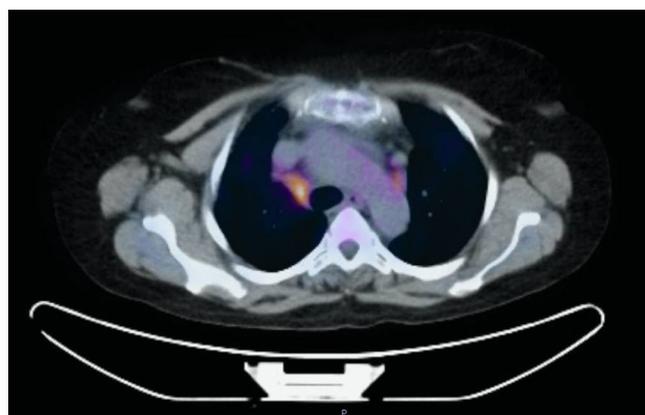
PET/CT with hypermetabolic focus in the right lower paratracheal lymph node station (4R).
